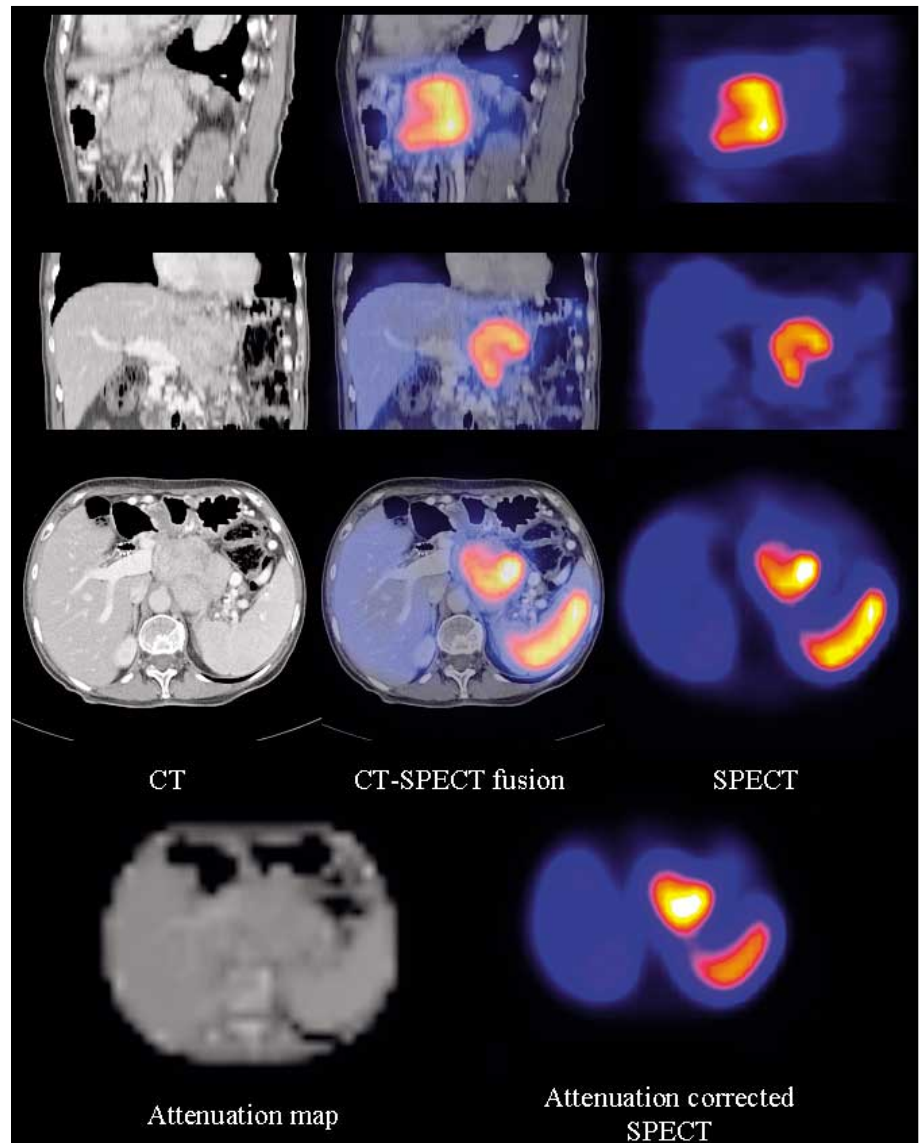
Metastatic lesion of a neuroendocrine tumour located in front of the aorta just below the pancreatic tail. Corresponding transaxial slices from CT and reconstructed indium-111 pentetreotide SPECT as well as fusion image, attenuation map, which represents the attenuation coefficients for each pixel in a 64×64 matrix, and resulting attenuation corrected SPECT image are shown. SPECT images are calibrated to their own maxima, white is indicating the highest values. Note increases in uptake values in the metastatic lesion on the attenuation-corrected image.
